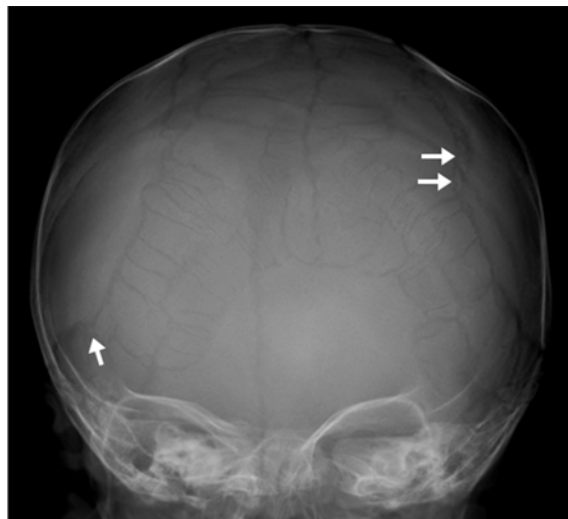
Skull radiography showed wormian bones.
